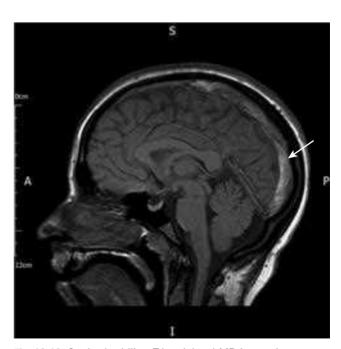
Sagittal midline T1-weighted MR image in a young woman presenting with headache and papilloedema. There is extensive thrombosis of the posterior half of the superior sagittal sinus (arrow)
